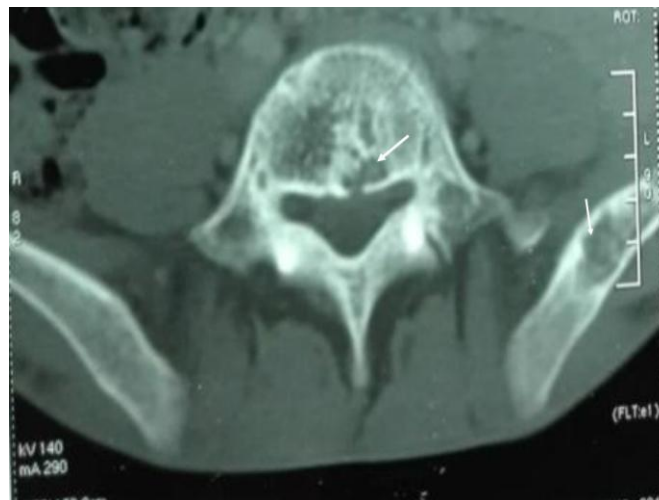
Vertebral and iliac bone langerhans cell histiocytosis in CT tomography
